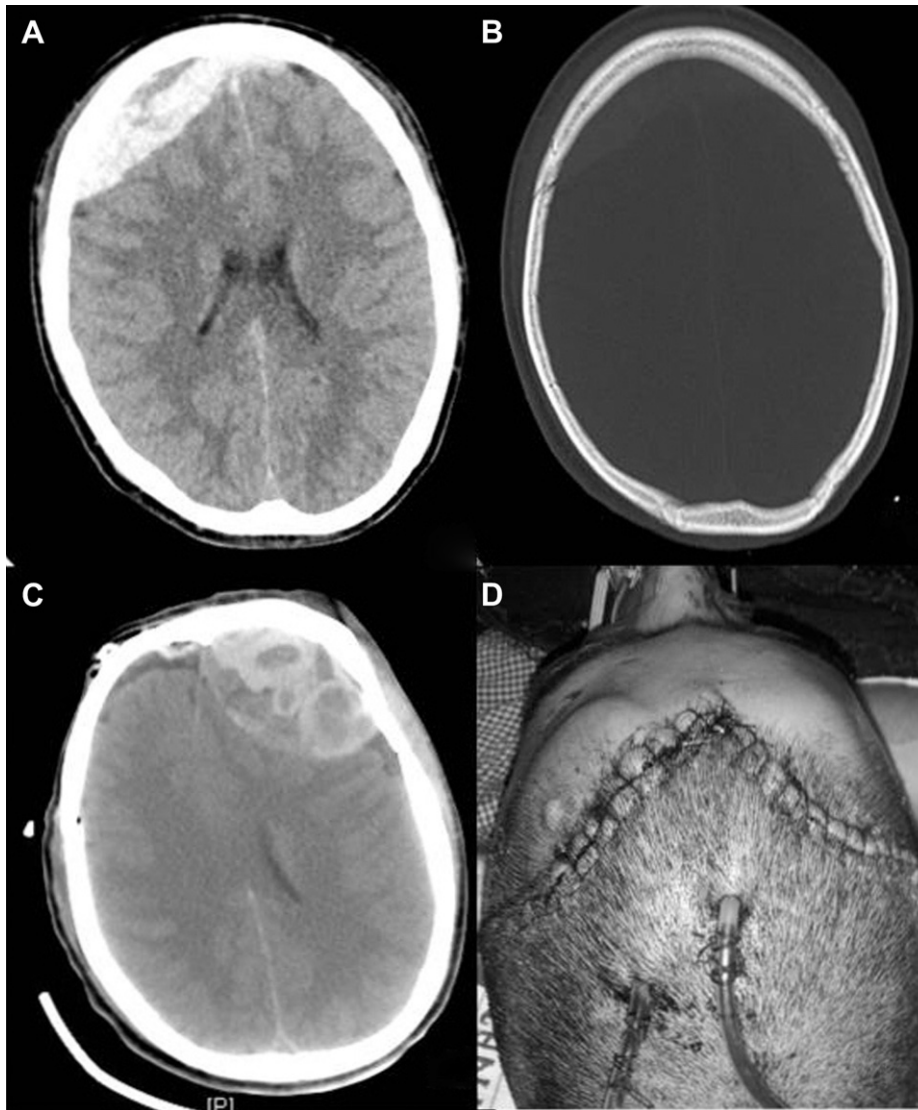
A. Plain CT head showing EDH of about 36 cc in right frontal convexity with minimal EDH across the superior sagittal sinus lying over the left frontal lobe. B. Bone windows showed no fracture of the vault. C. Delayed EDH as a mirror image, about 50 cc in the left frontal convexity, with evidence of right frontal craniotomy and evacuation of EDH. D. Bilateral frontal craniotomy wounds after the second surgery.
